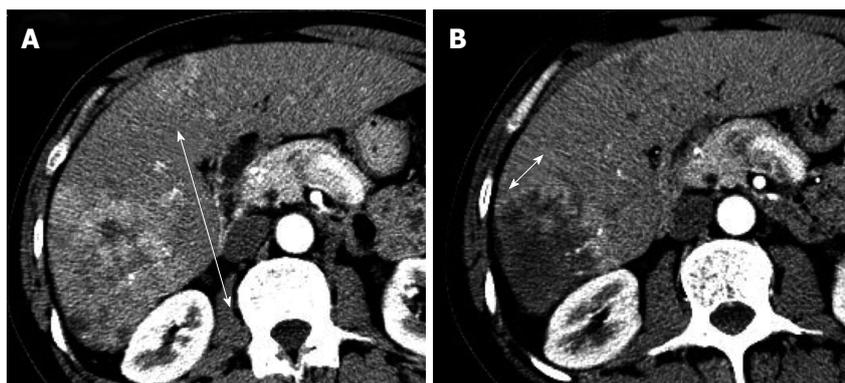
Application of modified Response Evaluation Criteria in Solid Tumor evaluation for hepatocellular carcinoma. A: Baseline; B: Post treatment. Tumor burden change was assessed on arterial-phase contrast enhanced diagnostic computed tomography image. Modified Response Evaluation Criteria in Solid Tumor evaluation should draw the maximal dimension of continuous arterial enhancement in such lesions with central necrosis, avoiding central necrosis.
